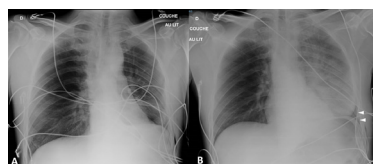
Chest X-ray performed in the postoperative room immediately after surgery (panel A) showed a normal expansion of the remaining left upper lobe, while chest X-ray performed at ICU admission (panel B) revealed a sudden opacification of the previously expanded left upper lobe with abnormal presence of air in the left costophrenic angle (white arrow heads) probably related to left upper lobe mispositioning.
